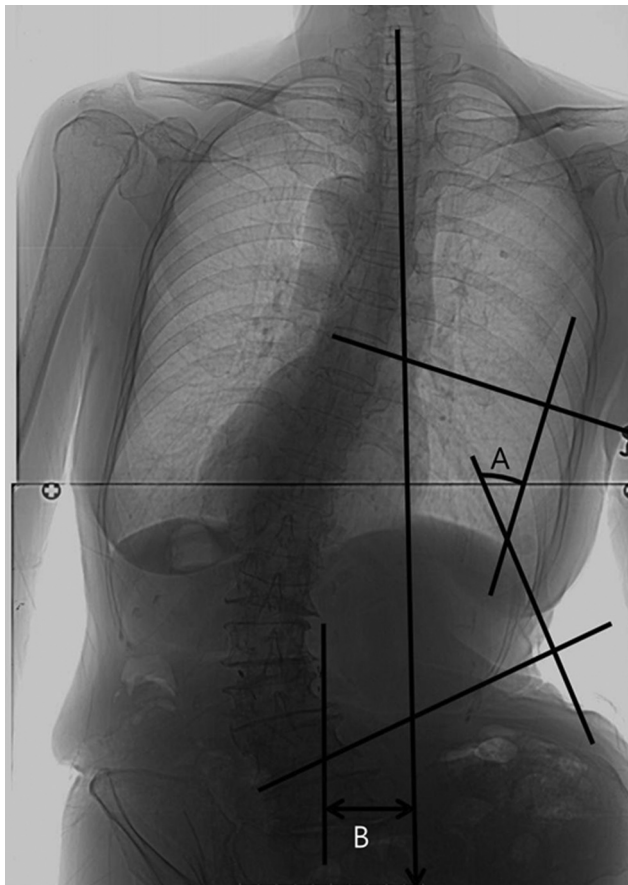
Parameters on plain X-ray anteroposterior view. (A) Cobb angle; (B) global coronal alignment.
